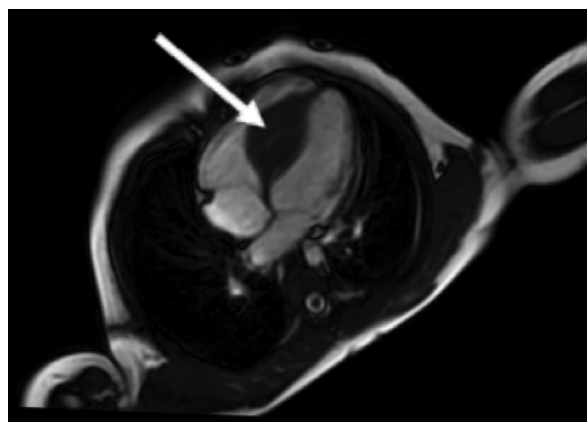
MRI of the heart., a $3.84 \times 5.07 \times 4$ cm tumour, most likely a fibroma, is present in the wall of the interventricular septum
